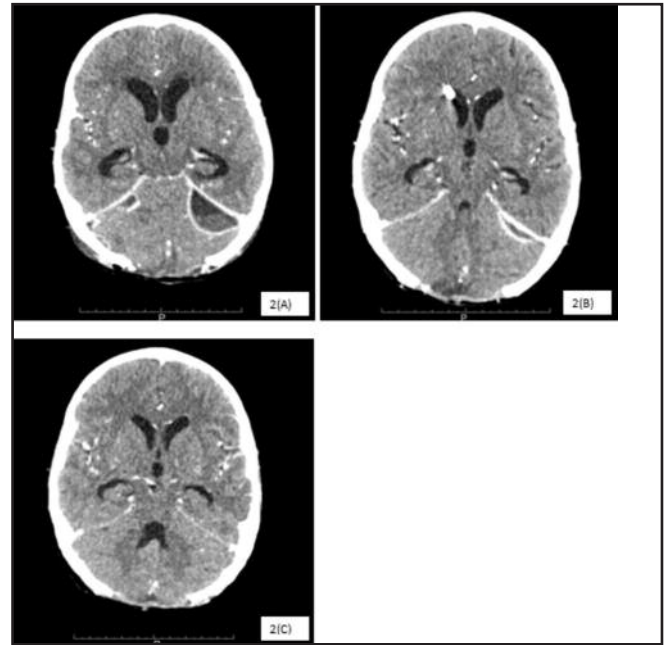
Serial contrast-enhanced CT scan of the patient's brain. (A) Re-collection of left subtentorial empyema at 2-week post drainage; (B) Resolution of left subtentorial empyema at 5-week post drainage; (C) Subtentorial empyema fully resolved at 7-week post drainage.
